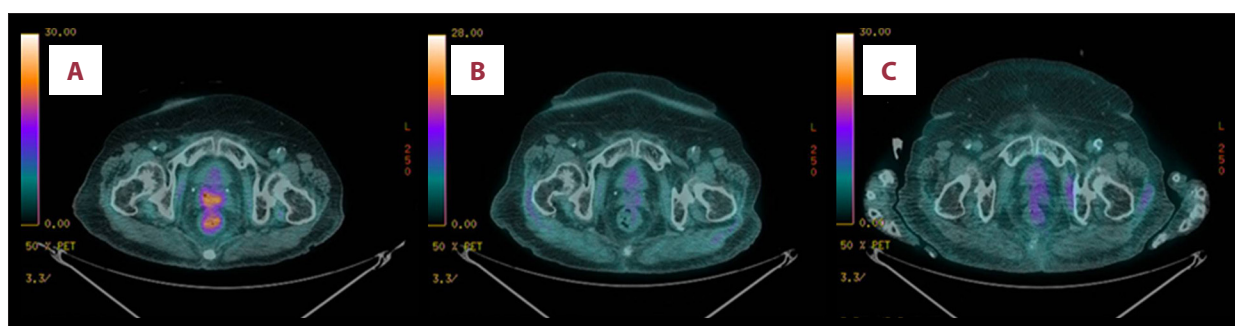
(A) FDG-PET/CT revealed recurrence of cervical carcinoma (9 months after primary CCRT). A glucose hypermetabolic lesion is located at the cervix. (B) The glucose hypermetabolic lesion completely disappeared 28 months after tamoxifen use. (C) No evidence of recurrence of cervical carcinoma on subsequent follow-up FDG-PET CT done 40 months after tamoxifen use.
